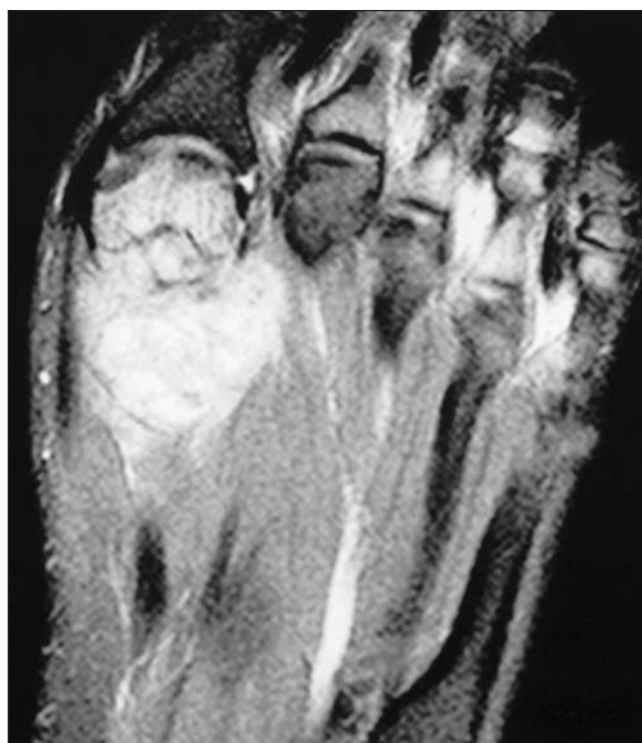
Coronal fat saturated proton density sequence magnetic resonance image of the foot.
